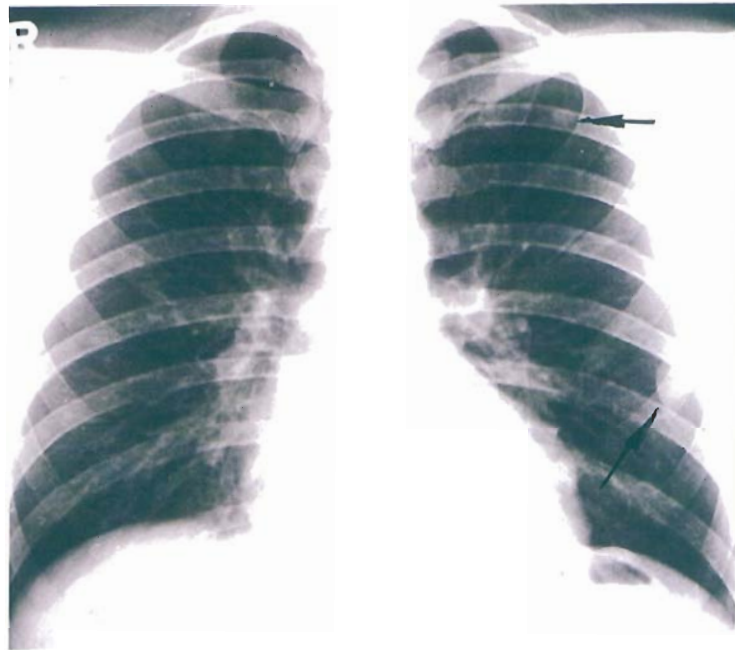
A patient with metastatic bladder cancer in the left chest (arrowed). Eighteen months before this x-ray he had had combined microwaves and X-ray Therapy for a carcinoma of the bladder with complete regression of the tumour. His bladder was clear on examination when this chest x-ray was taken on 22 April 1993.
